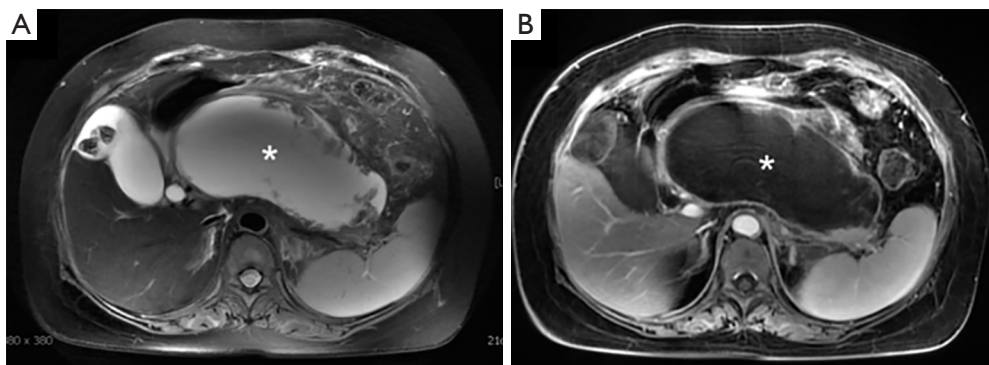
WON of the pancreatic head, body, and a portion of the tail in a 43-year-old woman with necrotizing pancreatitis 24 days after onset. The axial T2-weighted, fat-suppressed image (A) and enhanced T1-weighted image (B) reveals a marginal cystic envelope with uneven thickness and patchy necrosis with no enhancement of the necrotic tissue (asterisk). WON, walled-off necrosis.
